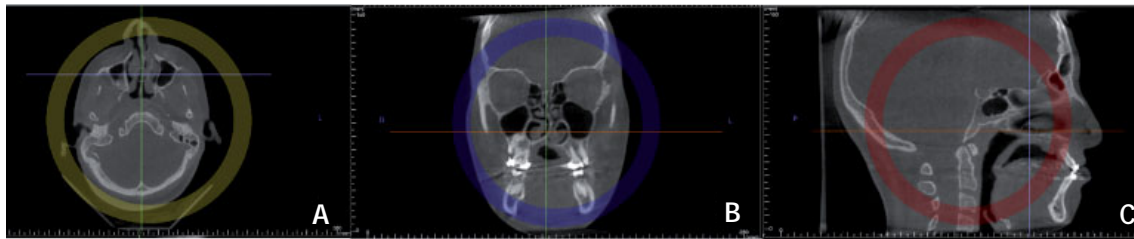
Example of a CBCT record. A: Axial view, B: Frontal view, C: Sagittal view
